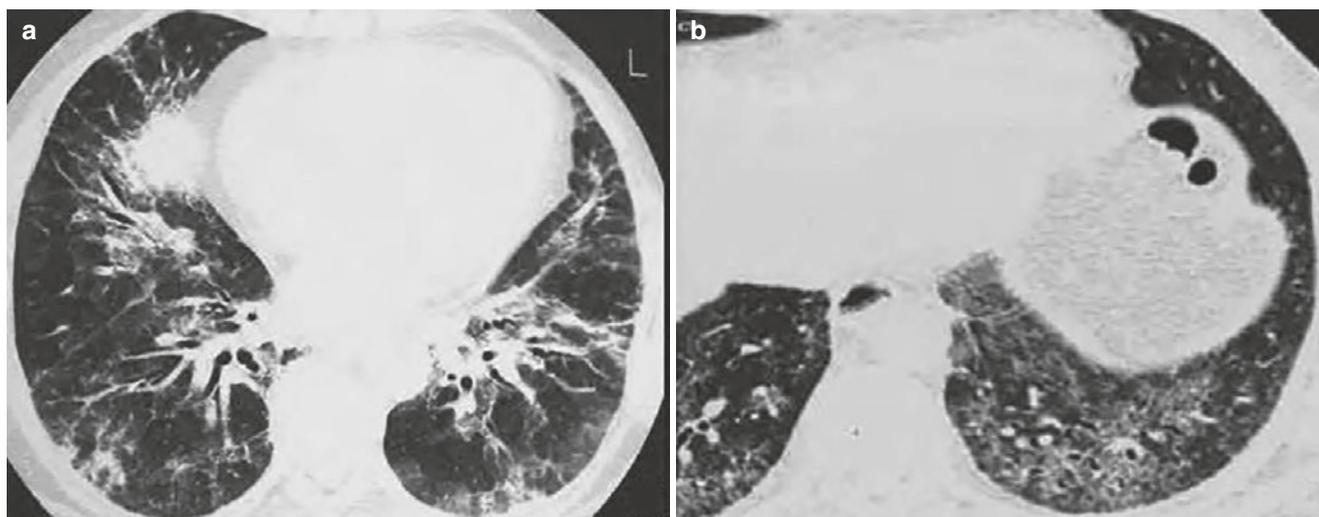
Nonspecific interstitial pneumonia. (a) CT lung window showed ground-glass opacities of both lungs, with patchy distribution, mostly in subpleural areas, accompanied by small patchy consolidation; (b) Irregular linear opacities and traction bronchiectasis
